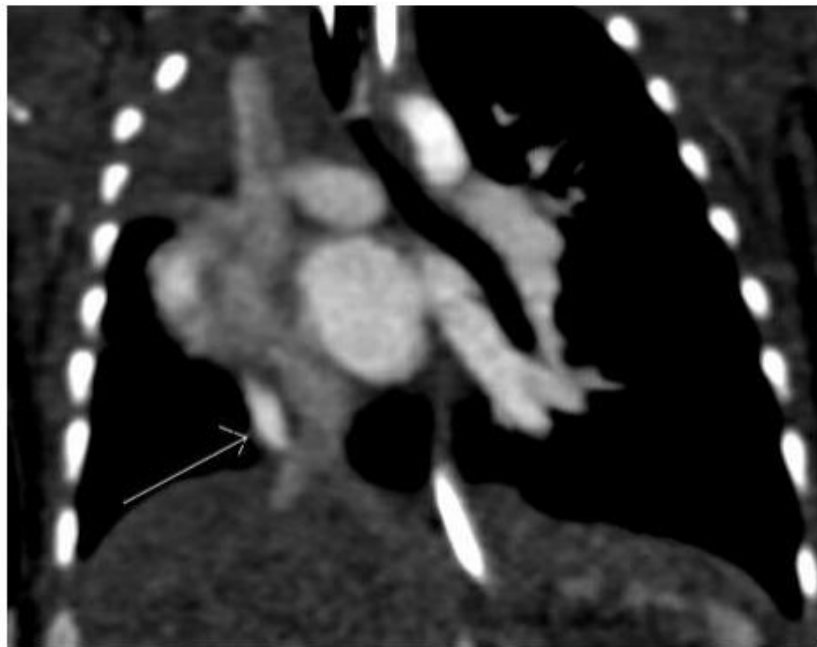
CTA of patient that diagnosed scimitar syndrome. Arrow demonstrating the pathognomonic finding. Also note the dextrocardia secondary to lung hypoplasia.
